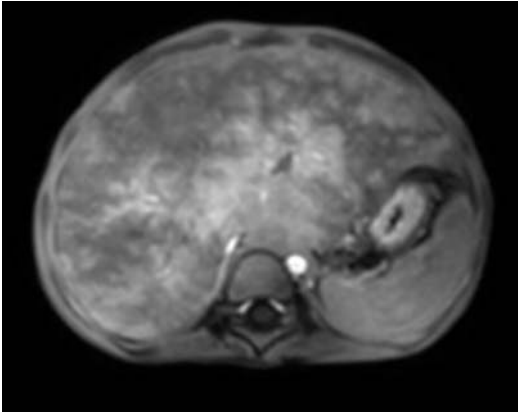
Post-contrast arterial phase axial T1-weighted MR image in a known case of Budd-Chiari syndrome showing hypointense signal in the periphery of the liver as compared to the central portion
